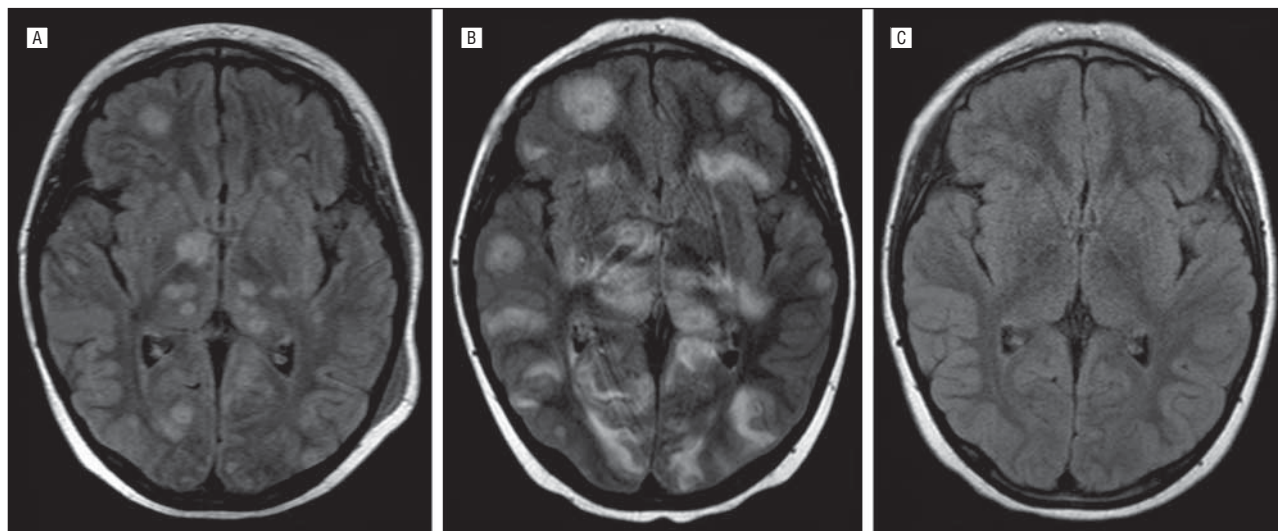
Axial fluid-attenuated inversion recovery magnetic resonance imaging sequences. A, Multiple brain tuberculomas at the time of diagnosis. B, One month after treatment, there was enlargement of the lesions, worsening of the surrounding edema, and the development of new lesions. C, Five months later, a new scan showed disappearance of the lesions.
